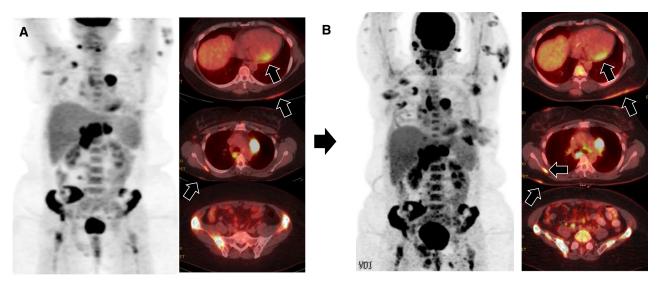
Coronal MIP and sample fused axial FDG PET-CT images using 72-hour HFHPVLC diet preparation before (\mathbf{A}) and after (\mathbf{B}) 17-month steroid therapy demonstrating progression of disease. Predominant disease is present in the mediastinum, upper abdomen, and bony pelvis. More subtle disease progression is present in the myocardium, skin, and right scapula (*arrows*).
